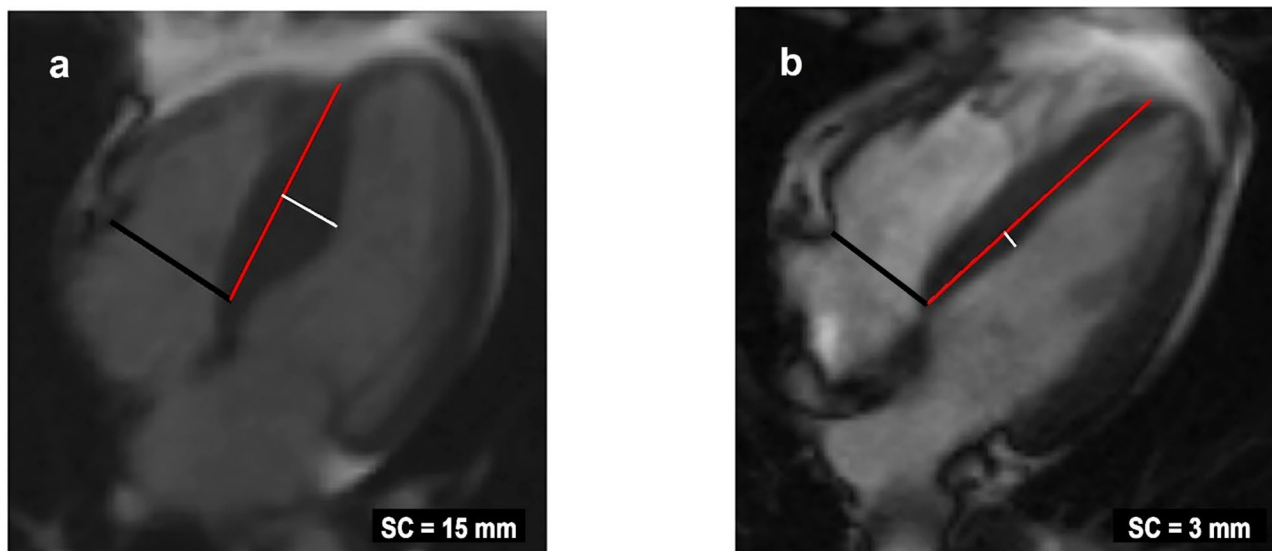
Measurement of septal convexity (SC) in end-diastolic 4-chamber cardiac magnetic resonance images (a) from a subject with hypertrophic cardiomyopathy and (b) from a subject with hypertensive heart disease. The black line is the tricuspid valve annulus. The red line is a reference line between the septal mid-wall at the level of the tricuspid valve and the insertion point of the right ventricle into the left ventricle at the apex. The white line represents the measured SC.
